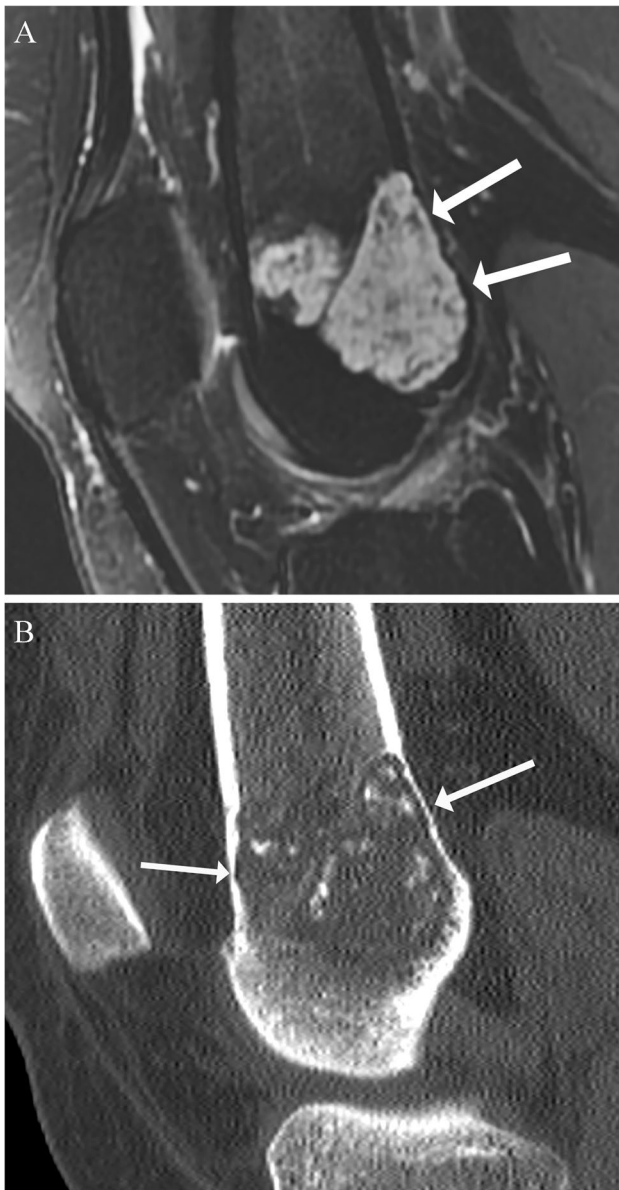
A 46-year-old woman with atypical cartilaginous tumor and pain in the knee. (A) T2-weighted fat-suppressed images shows a chondroid lesion in the distal femoral metaphysis with marked endosteal scalloping (arrows) in the posterior cortex. (B) On the sagittal CT image, the lesion contains multiple curvilinear calcifications with deep endosteal scalloping (arrows) in the anterior and posterior cortex. Bone scan shows mild uptake in the left distal femur (not shown). Pain resolved after curettage of the lesion
